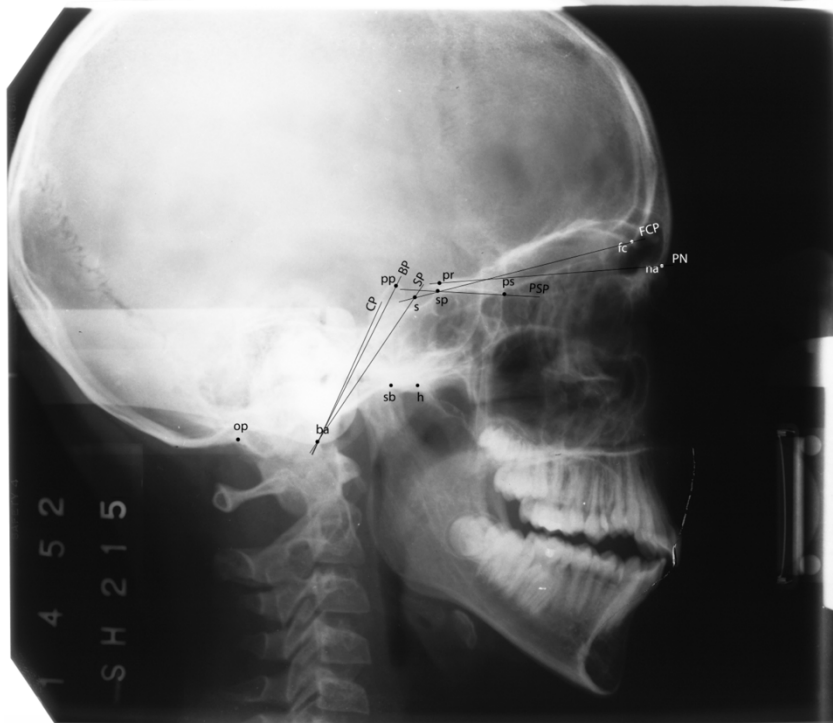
Landmarks and planes located on a radiograph used in this study. Landmarks are labeled in lowercase, and planes in capital letters.
